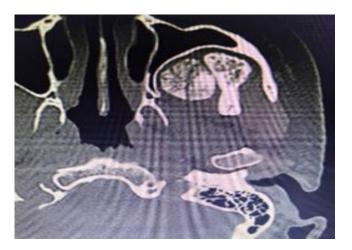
Computed tomography of the base of the skull where an increase in volume is observed in the temporomandibular joint.
